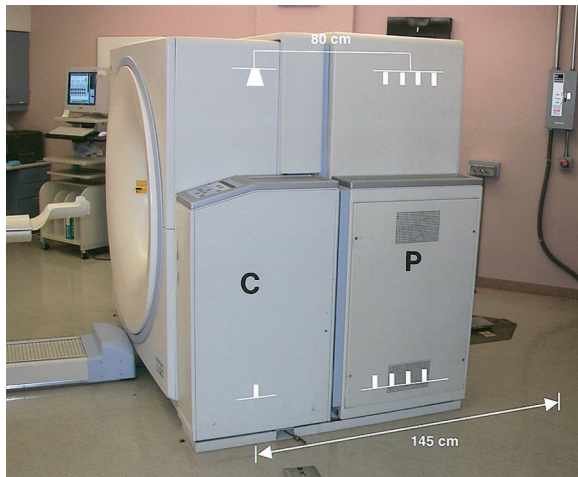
Photograph (side view) of a hybrid PET-CT scanner shows the PET (P) and CT (C) components. The distance between the PET and CT scanners is 80 cm, and the maximum coverage that can be achieved during a combined study is 145 cm. The PET and CT scanners are mechanically independent and can be used in isolation for PET or CT only.
